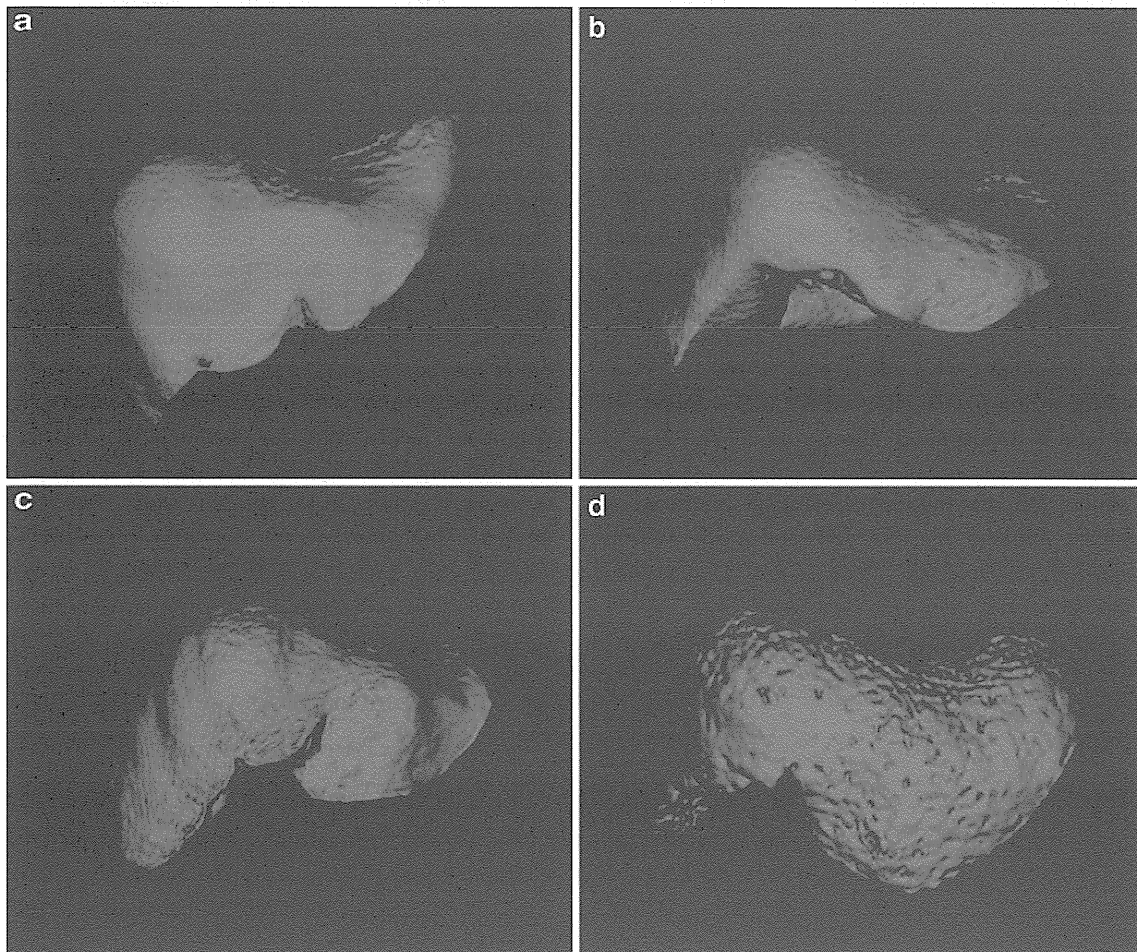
a Three-dimensional magnetic resonance image of nonadvanced liver fibrosis in nonalcoholic steatohepatitis (NASH), stage 1, showing a smooth liver surface and enlarged lateral segment. b Image of nonadvanced fibrosis, NASH stage 2, showing localized small irregularities of the surface of the liver and an enlarged lateral
